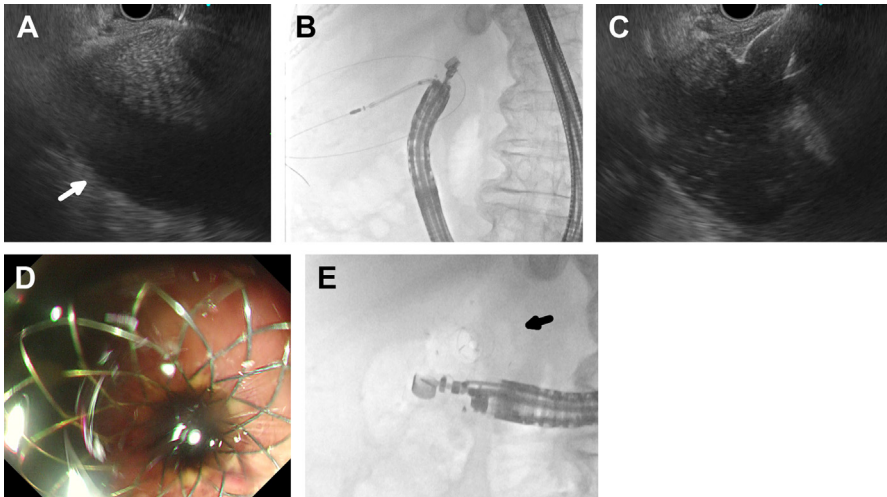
(A) EUS noted a distended gallbladder as indicated by the white arrow. (B) Direct puncture with the cautery enhanced LAMS and insertion of a guidewire into the gallbladder. (C) Opening of the distal flange under EUS guidance. (D) Endoscopic view of the proximal flange. (E) X-ray image of a fully opened stent.
